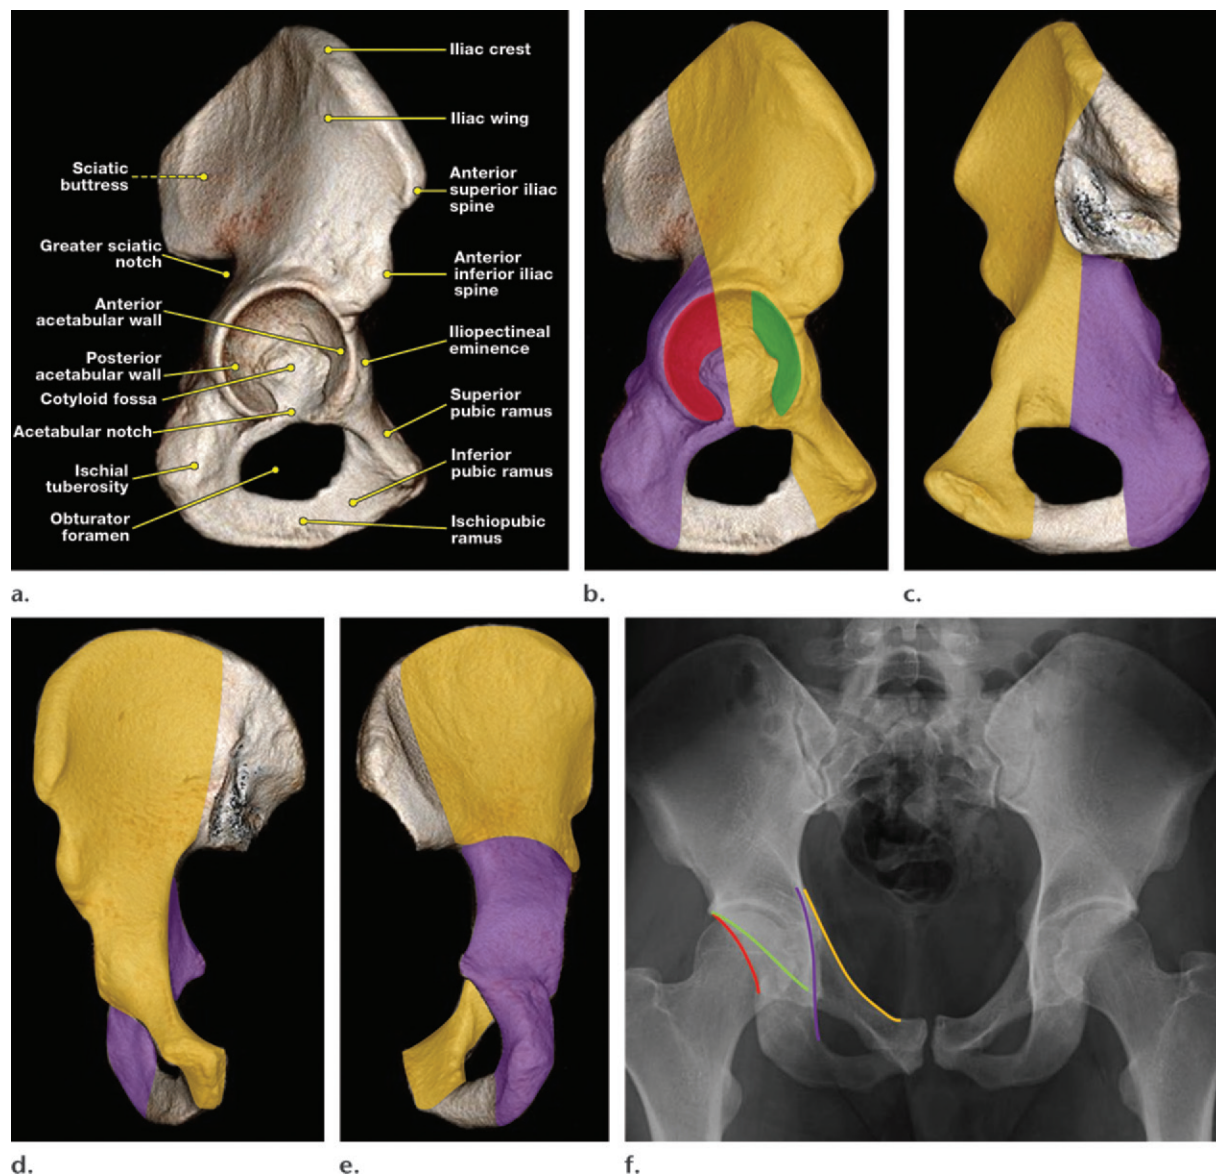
Acetabular anatomy. (a) Lateral surface-rendered 3D CT image shows the acetabulum. (b–e) Lateral (b), medial (c), anterior (d), and posterior (e) 3D CT images show the anterior column (yellow area), anterior articular surface (green area), posterior column (purple area), and posterior articular surface (red area) of the acetabulum. (f) Frontal radiograph of the pelvis shows the iliopectineal line (yellow line), ilioischial line (purple line), anterior acetabular wall (green line), and posterior acetabular wall (red line).
